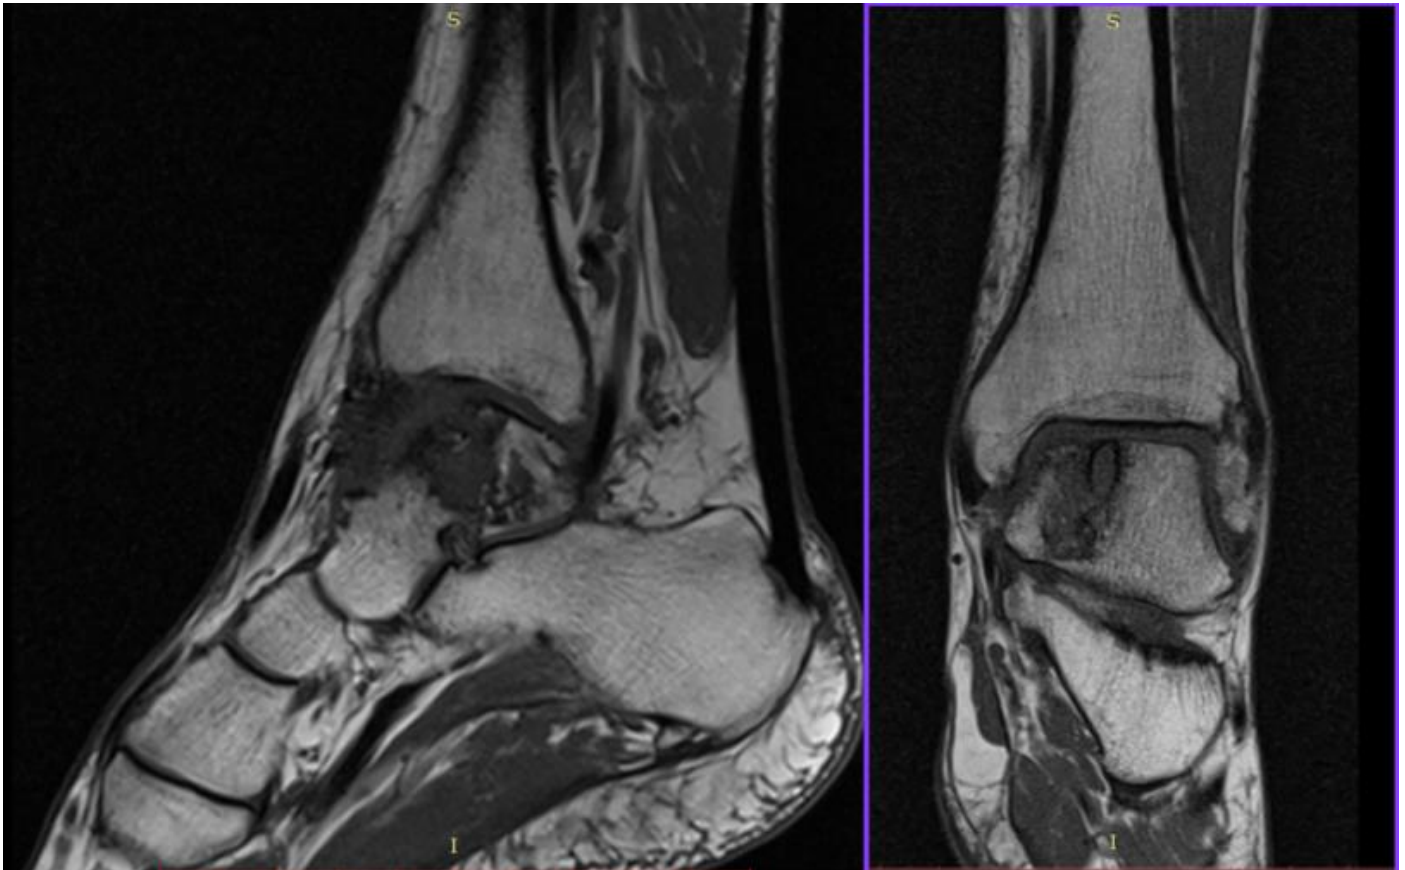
MRI T1 scans of the left talus bone in January 2020. before the second surgery showing multiple subchondral cysts
